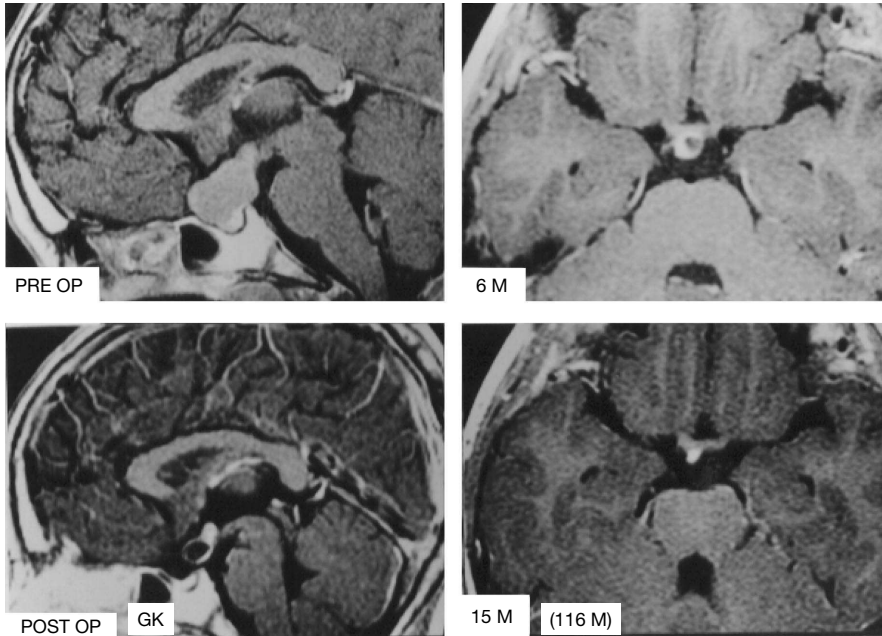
Small residual tumor at ‘R-site’ and follow-up MRI after GK. A 9-year-old boy had a suprasellar mass compressing the optic nerve (left). The tumor was subtotally resected and a small cystic tumor (13.6 mm) in the retrochiasmal region was treated by Gamma Knife radiosurgery using a marginal dose of 15 Gy and 5 isocenters (RS). The tumor was decreased in size at 12 months (12), CR was obtained at 15 months, and the tumor has been stable for more than 116 months to date (116). Mental and physical development normalized after treatment and the patient graduated from university.
